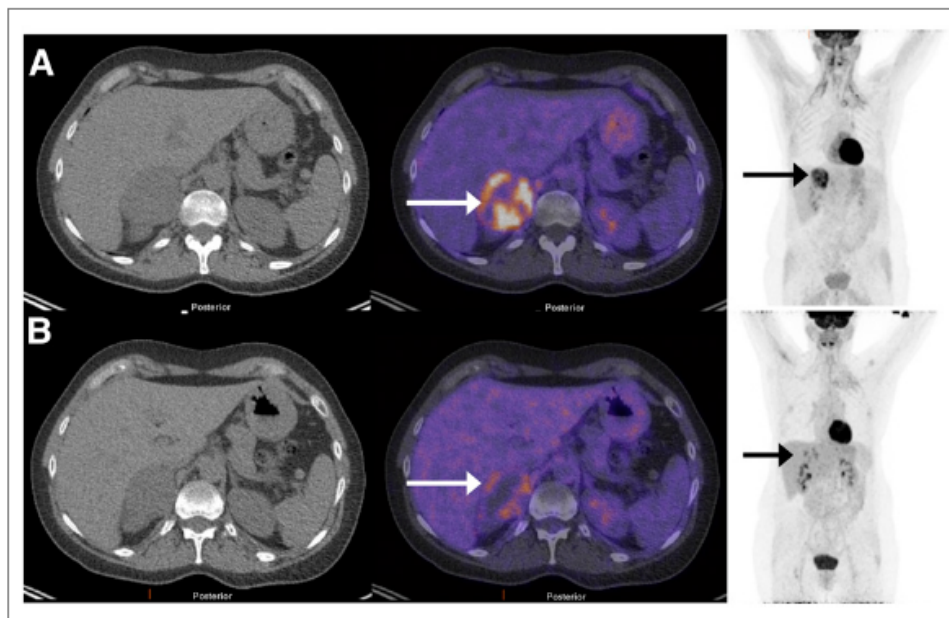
Baseline (A) and in-treatment (B) ^{18}F -FDG PET/CT in a 51-y-old female patient with NSCLC, stage IVB, with Pancoast tumor in left lung with metastasis in right adrenal gland (white and black arrows). In-treatment ^{18}F -FDG PET/CT showed apparent decrease in uptake classified as PMR. Survival was 12.4 mo.
